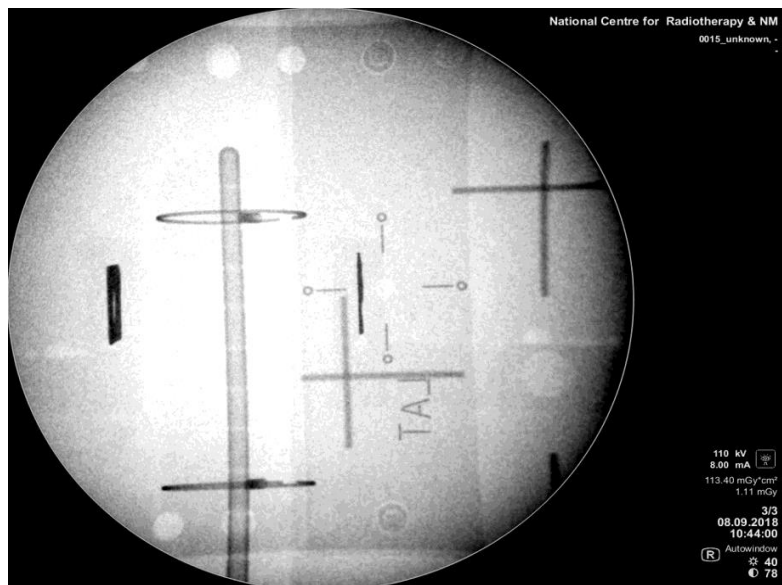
Lateral radiograph (LAT) of the Applicator (Cylinder only)
